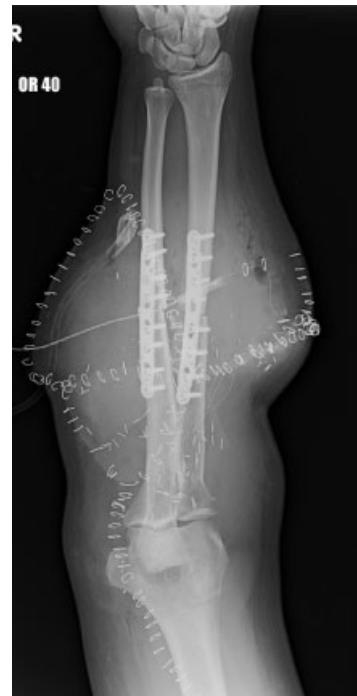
Radiograph depicting a mid-forearm transplantation's radius and ulna rigid osseous fixation using 3.5-mm Locking Compression Plates.
